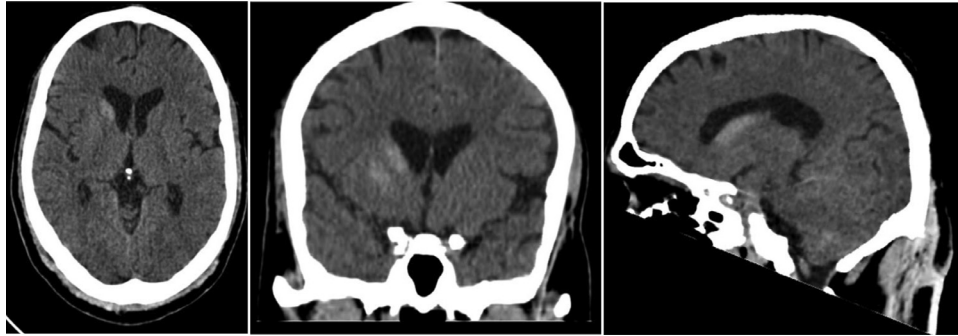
Axial, Coronal, and sagittal cuts of plain brain CT scan: demonstrating right basal ganglia hyperdensity.
